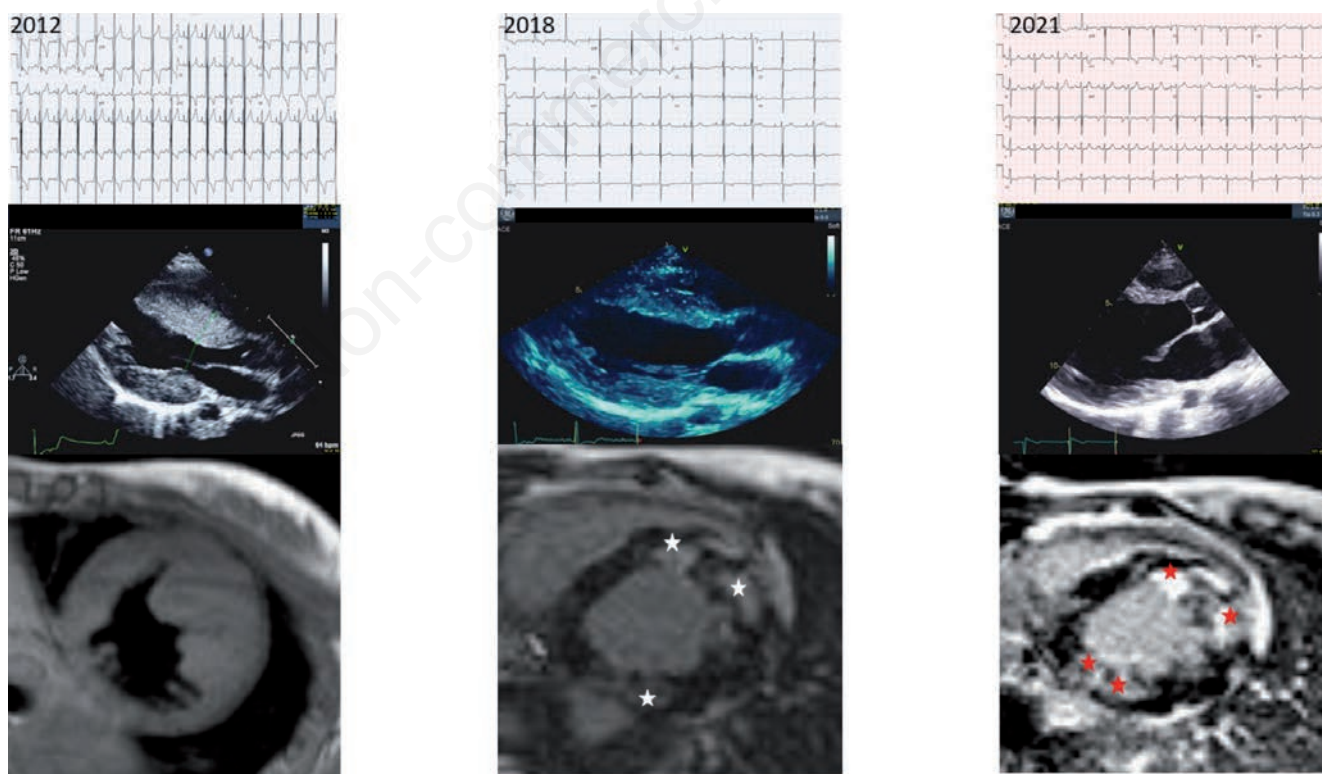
Evolution from HCM to dilated cardiomyopathy. Patients with hypertrophic cardiomyopathy evolved to dilated cardiomyopathy after 10 years. 2012: Severe asymmetric hypertrophy. 2018: Diffuse patchy fibrosis, non-ischemic pattern, consistent with non-obstructive hypertrophic cardiomyopathy. 2021: Abnormal dyskinetic ventricular wall motion abnormalities. Eccentric hypertrophy with abnormal trabeculations on the apical and lateral wall segments. Fibrosis at the ventricular septum at right ventricular insertion sites. Stars indicate fibrosis at MRI.
